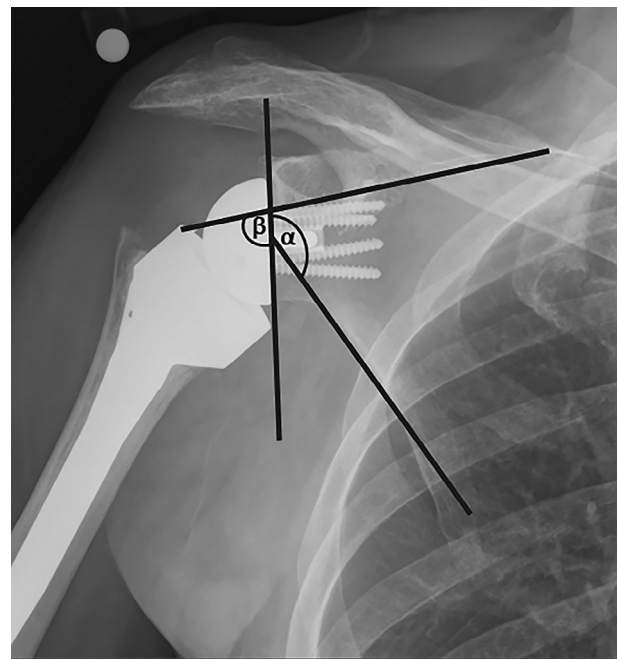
Definition of α and β angles used to assess change in inclination.^{4,13} For preoperative radiographs, the vertical line represented the native glenoid face.
